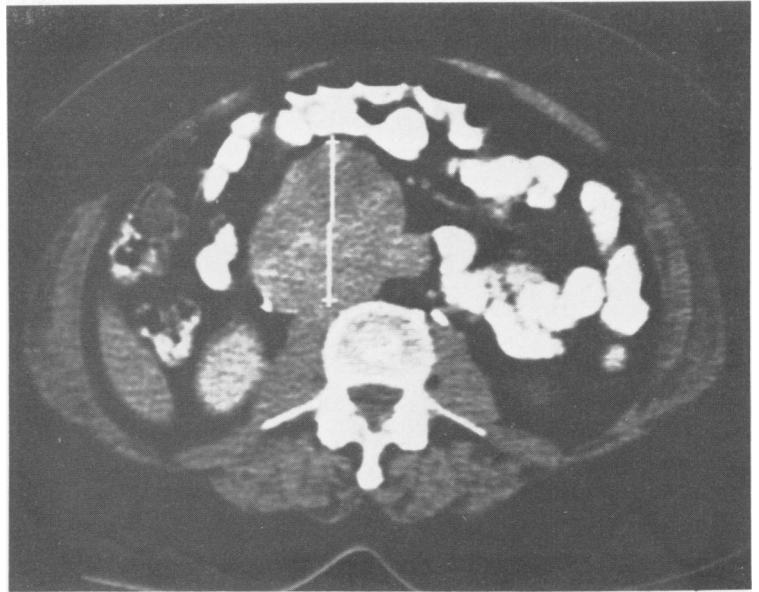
Case 3—CT scan of abdomen showing large retroperitoneal mass adjacent to aorta. IVC not identifiable.
